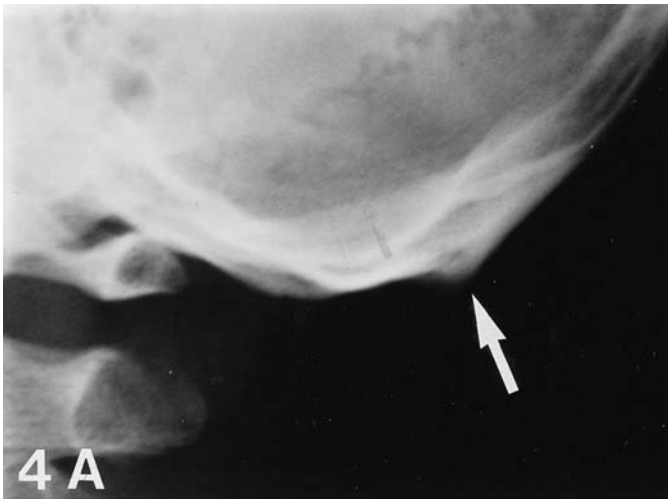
Spine like (Type 3) external occipital protuberance (arrow) in a female. A) Lateral cranium radiograph. B) Dry skull photograph.
